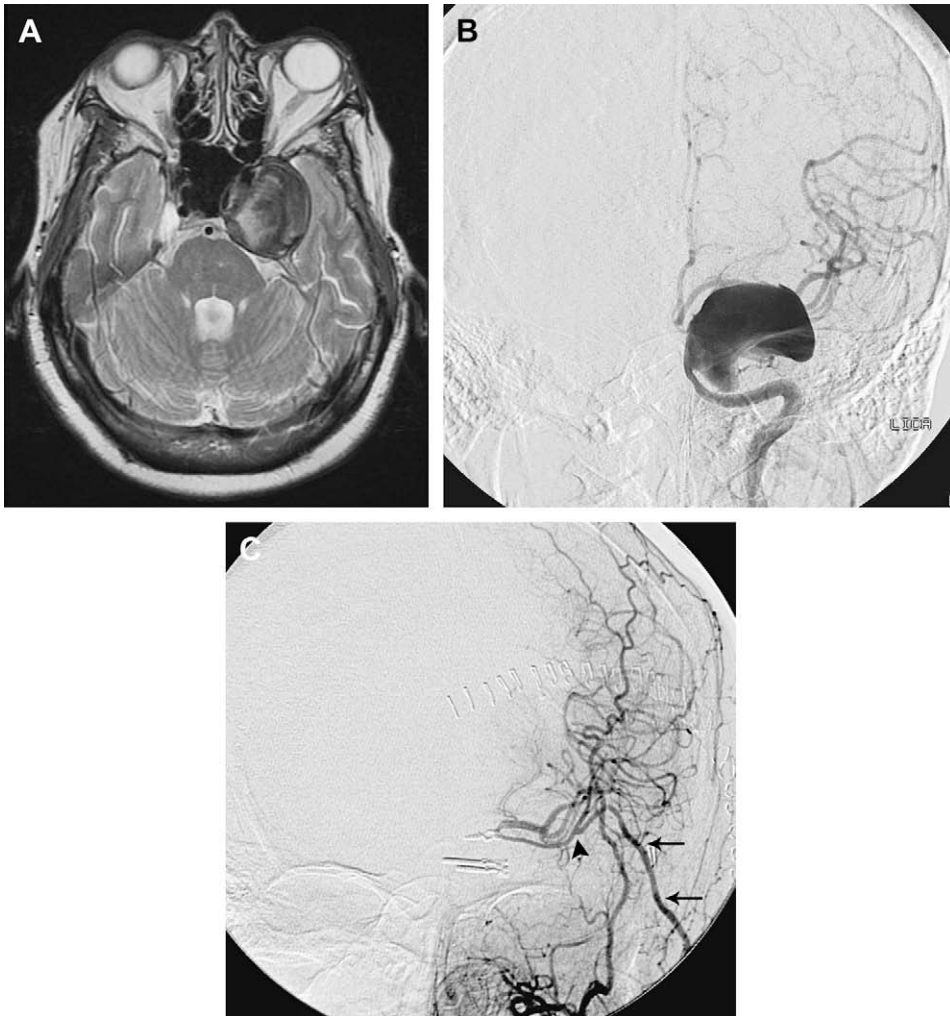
Symptomatic giant partially thrombosed cavernous carotid aneurysm. (A) Axial T2-weighted MRI demonstrating the partially thrombosed aneurysm. (B) Partial filling of the aneurysmal sac is demonstrated on the anteroposterior carotid angiogram. The patient passed BOT clinically but demonstrated hypoperfusion in the left hemisphere on SPECT during the hypotensive challenge. Intraoperatively, a flow deficit of 15 mL/min was measured in the MCA trunk. The STA flow was found to be adequate to replace this deficit, and the patient underwent STA-MCA bypass with trapping of the aneurysm. (C) AP postoperative angiogram demonstrates excellent filling of the MCA territory via the STA (arrows) through the patent anastomosis (arrowhead).
